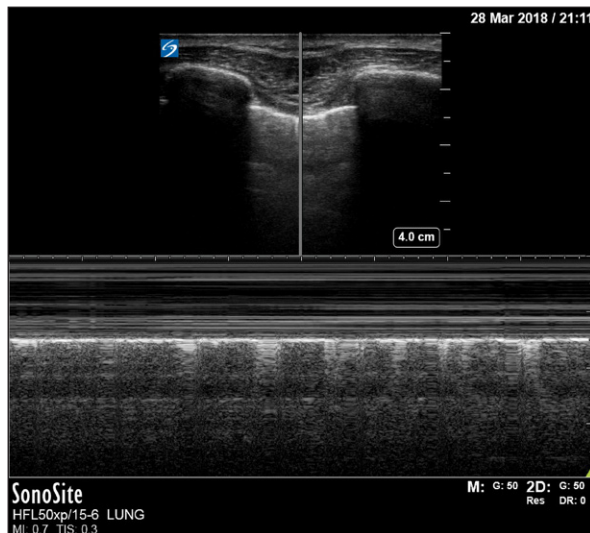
Normal lung – M-mode ultrasound image
